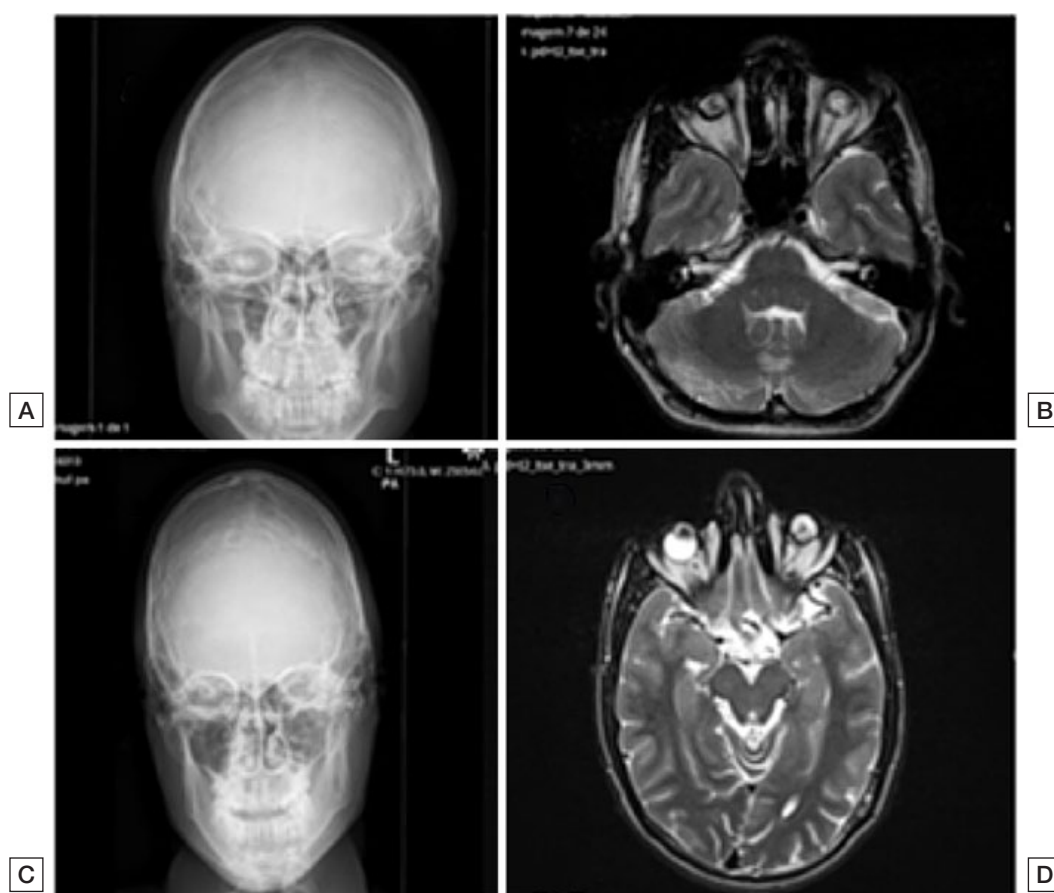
Skull radiograph and head MRI of the older [A and B] and younger [C and D] brothers. Dolichocephaly is more pronounced in the younger sibling [C]. Microphthalmia [B and C].
